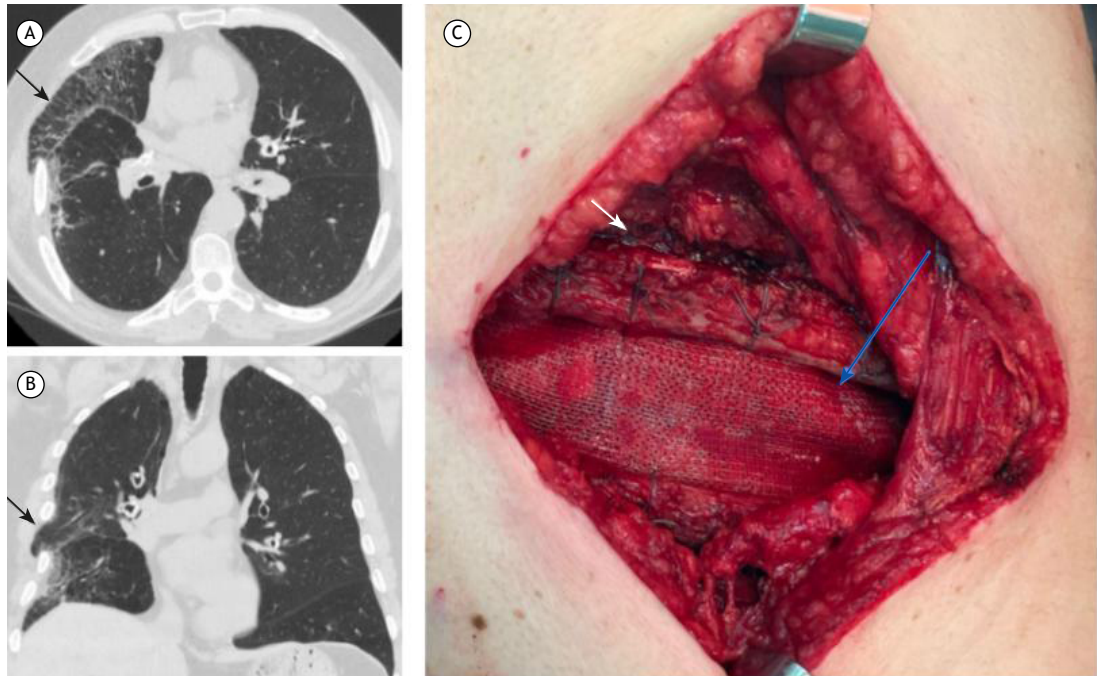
Axial and coronal CT scans of the chest during a Valsava maneuver (in A and B, respectively). In C, a photograph showing a prolene mesh patch attached to the costal margins with nonabsorbable suture at the parietal pleural level covering the defect.
